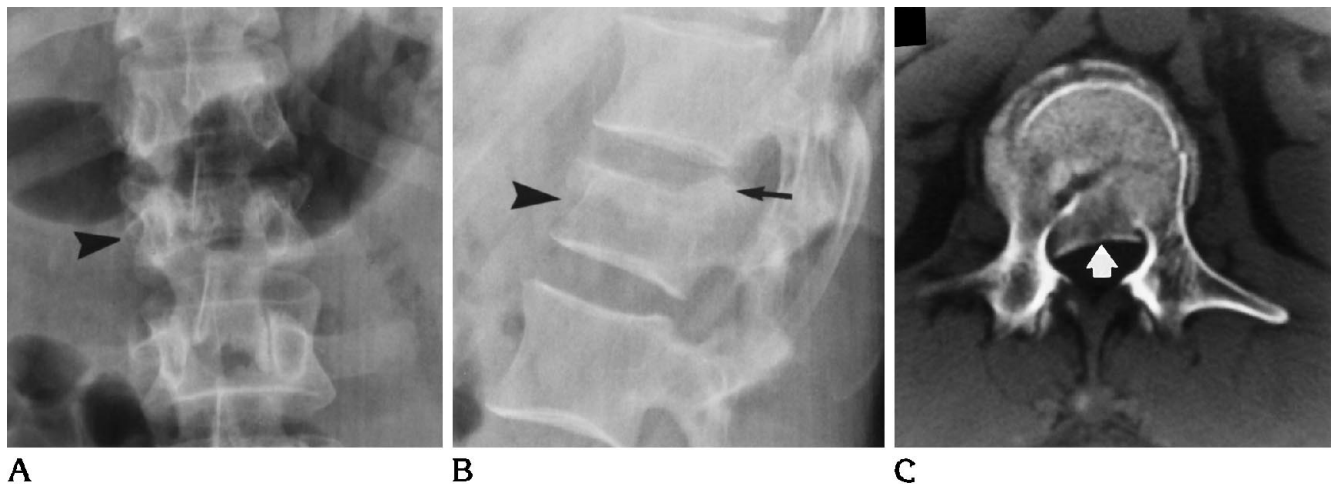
A* and *B*, Plain films (anteroposterior and lateral) of an L-1 fracture (*black arrowheads*). The posterior vertebral line is indistinct (*black arrow*), and the facet joints are not clearly seen. This was called stable by three of six plain-film readers. *C*, CT of L-1 reveals a burst fracture (*arrowhead*) with 25% to 50% spinal canal compromise.
